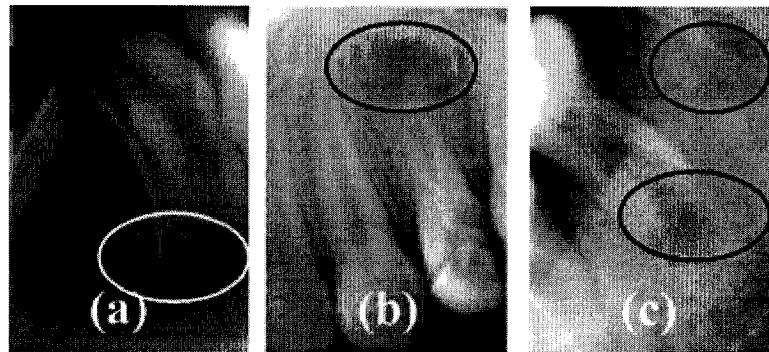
Dental X-ray samples.
